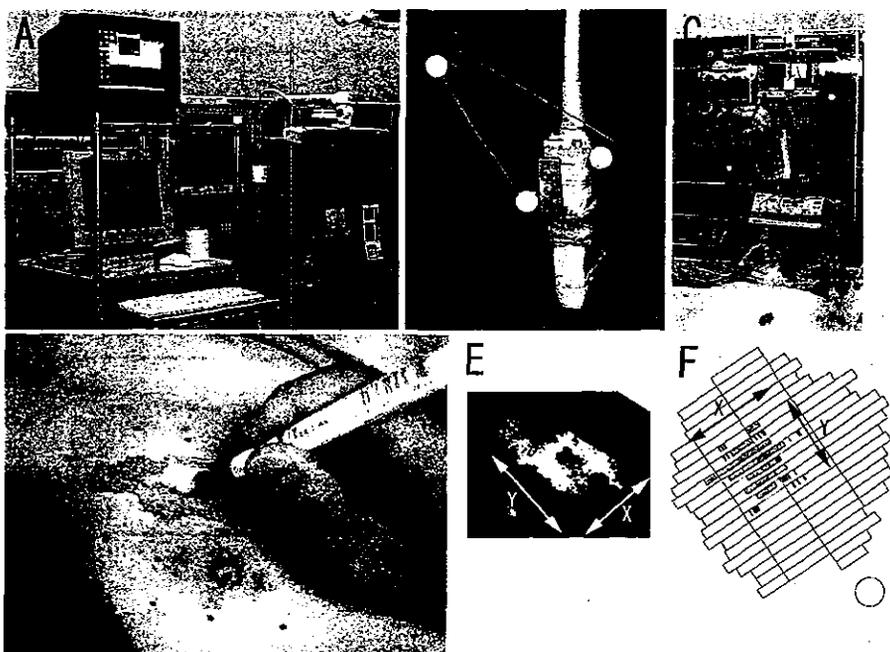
The real-time ultrasound navigation system is constructed of Polaris, a workstation (A), a ultrasound probe with reflection balls for Polaris (B) and a video camera (C). The reconstructed tumor image is superimposed on the patient's video image (D). The tumor size was measured in two directions using the 3D image (E) and pathological mapping (F).
